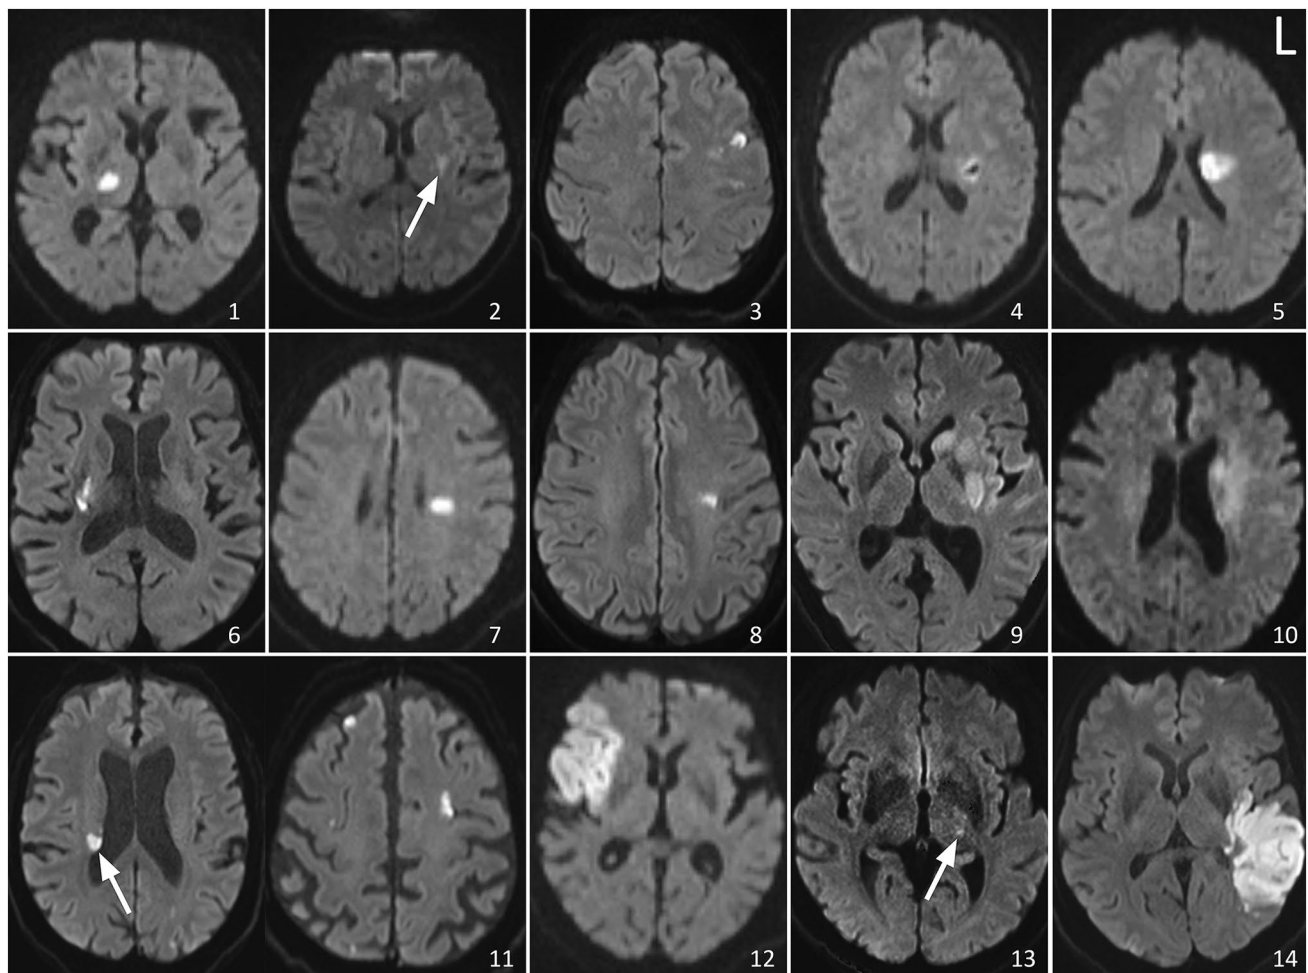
Magnetic resonance imaging (MRI) scans. Note that patient #11 suffered from multiple cardio-embolic lesions in both hemispheres (small cortical and sub-cortical lesions); the sub-cortical
